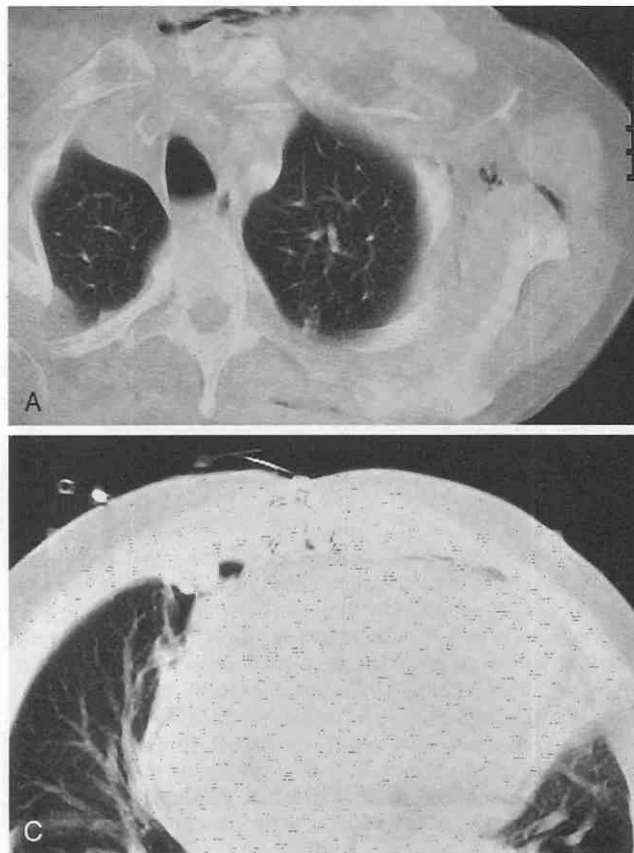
Pleuromediastinal cutaneous fistula in a 51-year-old man with coagulase-negative staphylococcal sternal wound infection 10 days after cardiac transplantation. A, CT scan shows subcutaneous empyema in the left chest wall. B, Nonenhanced CT scan obtained inferior to A shows air in the sternal dehiscence and in infiltrated anterior mediastinal fat, findings consistent with infection. C, CT scan obtained inferior to B shows more extensive pneumomediastinum and a right pneumothorax. (From Knisely BL, Mastey LA, Collins J, Kuhlman JE: Imaging of cardiac transplantation and complications. *Radiographics* 19:321, 1999.)
